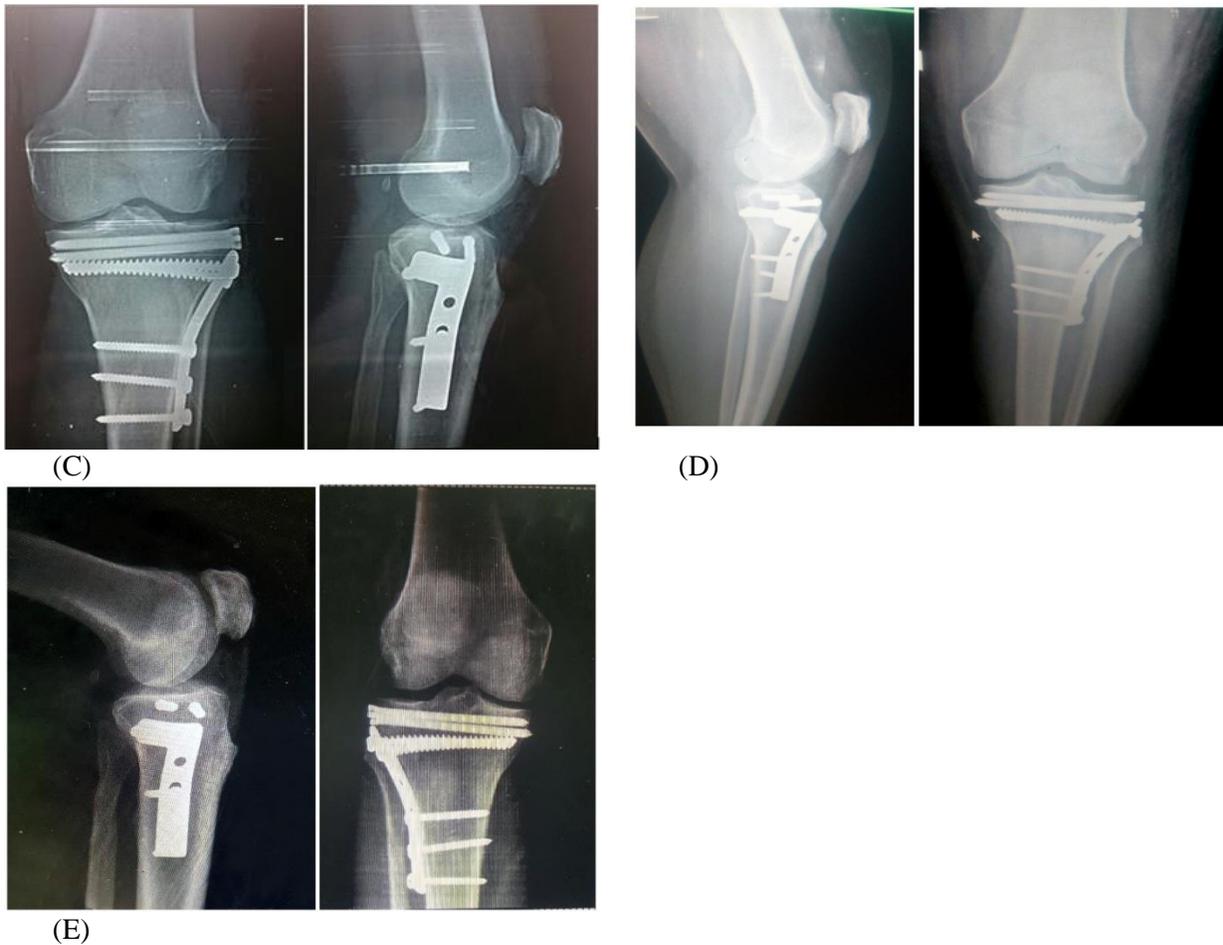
Case of raft screws: (A): -Preoperative x ray, (B): Preoperative CT scan, (C) :Immediate Postoperative X-Ray, (D): One-Month Follow up X-Ray, (D) :2 years Follow up X-Ray.
